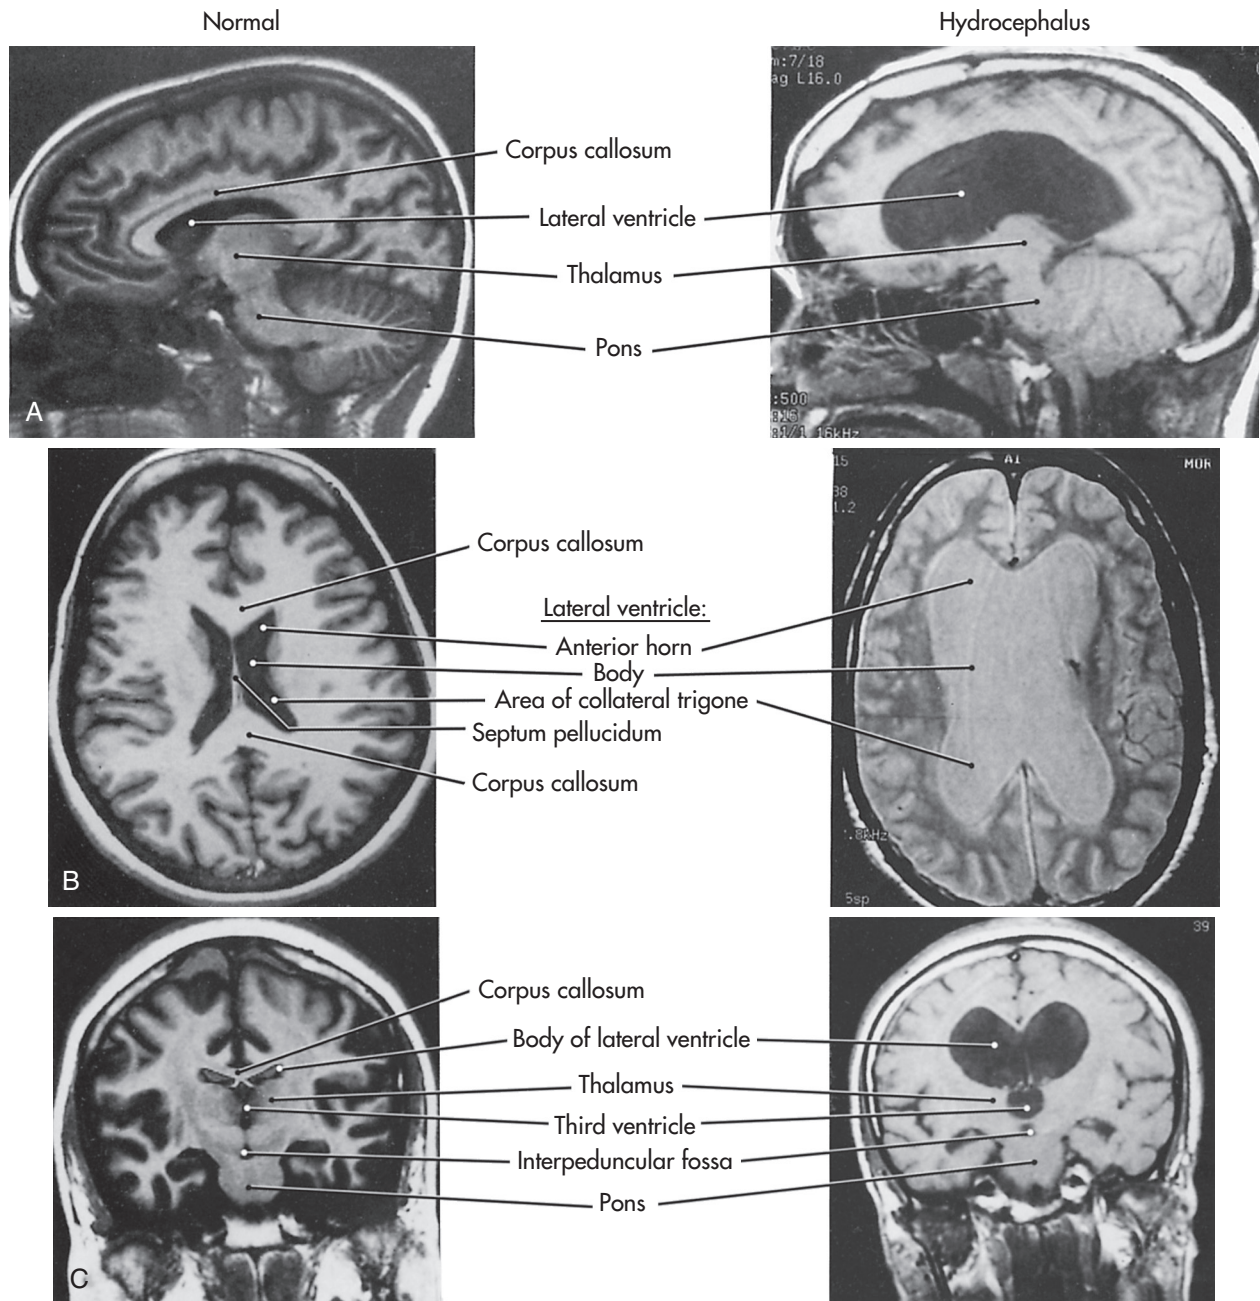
Comparison of Normal and Hydrocephalic Brains. A, Sagittal; B, axial; and C, coronal planes as seen in magnetic resonance imaging (MRI). (From Haines DE, editor: *Fundamental neuroscience for basic and clinical applications*, ed 4, Philadelphia, 2013, Saunders.)
